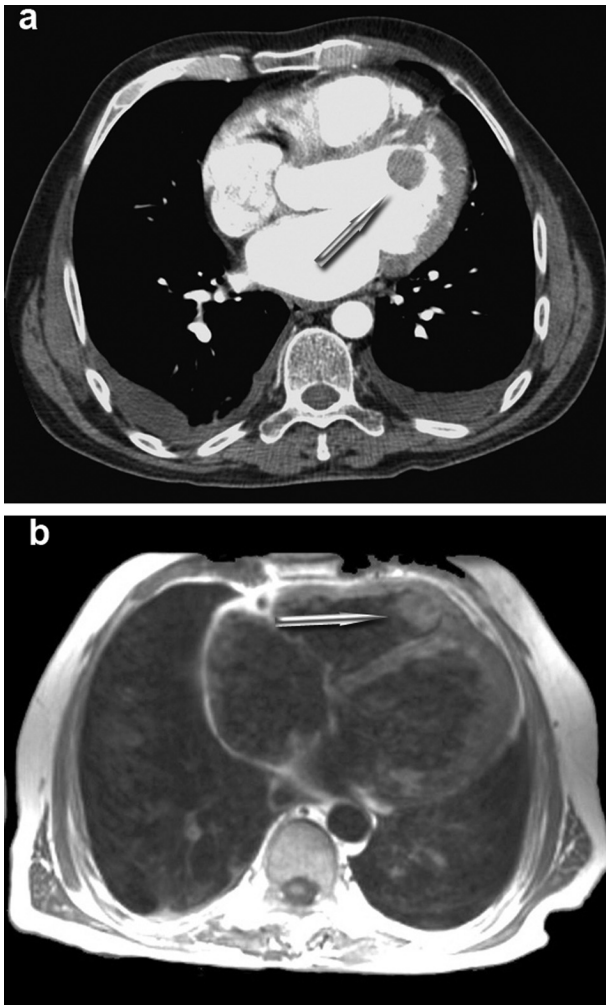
CT-Scan (a) and MRI (b) demonstrating tumor in the left and right ventricular cavity, respectively (arrows).
